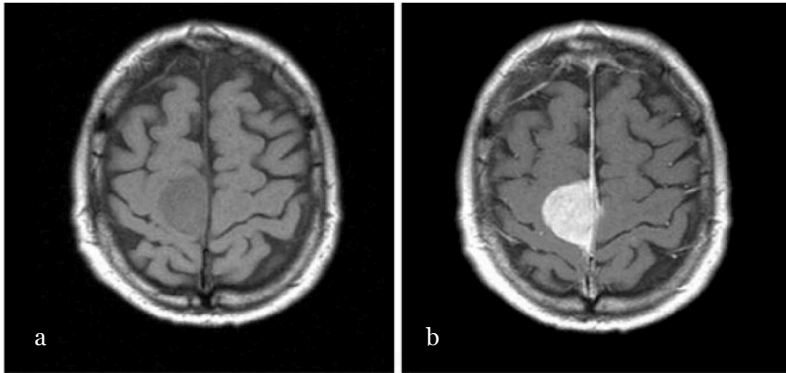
Meningioma* on the T1 channel, before and after contrast. (a) *Meningioma* hypointense on T1-weighted imaging, and (c) presents a homogeneous intensive contrast enhancement.
